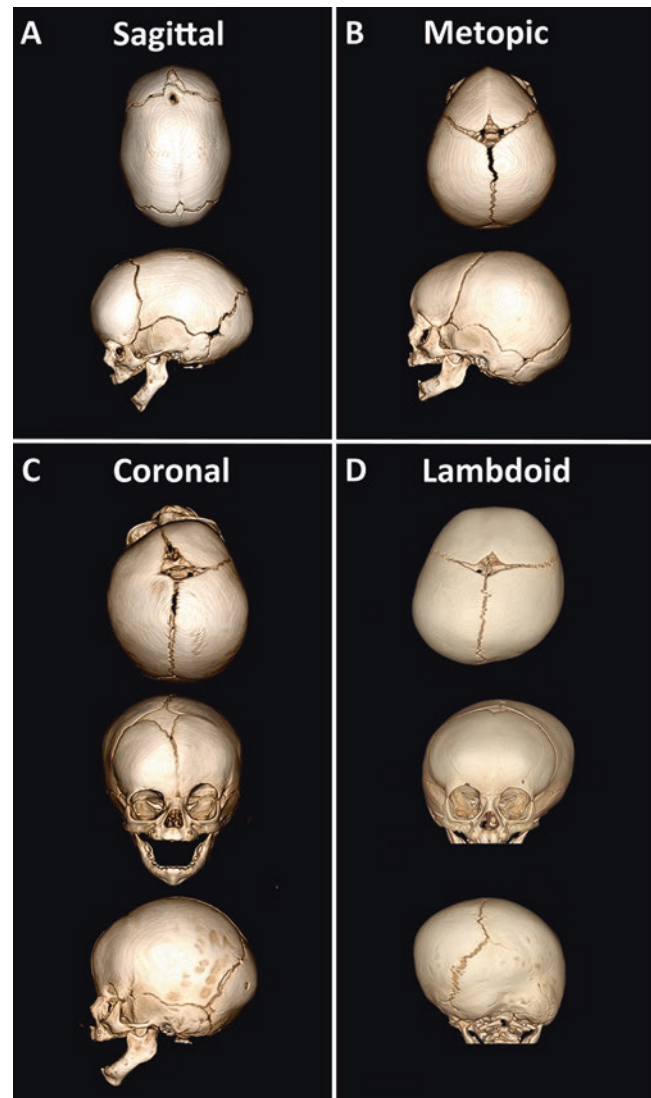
3D CT reconstructions from infants with single suture craniosynostosis. (a) Sagittal synostosis: top view shows fusion of sagittal suture with elongated skull and narrow biparietal width. Side view shows elongation with prominent occiput and frontal bones. (b) Metopic synostosis: top view shows trigonocephaly with orbital exposure. (c) Coronal synostosis: top view shows fusion of the left coronal suture, exposure of the orbit on the left side; frontal view shows orbital asymmetry and facial twist to the right side; side view shows fusion of the left coronal suture. (d) Lambdoid synostosis: top view shows skull asymmetry with prominence of the left parietal and occipital bones; front view also shows asymmetry; back view shows fusion of the right lambdoid suture, asymmetry of the skull base, and a right mastoid bulge. Note that the metopic suture has fused normally in this patient because of age, not pathologically associated with metopic craniosynostosis
